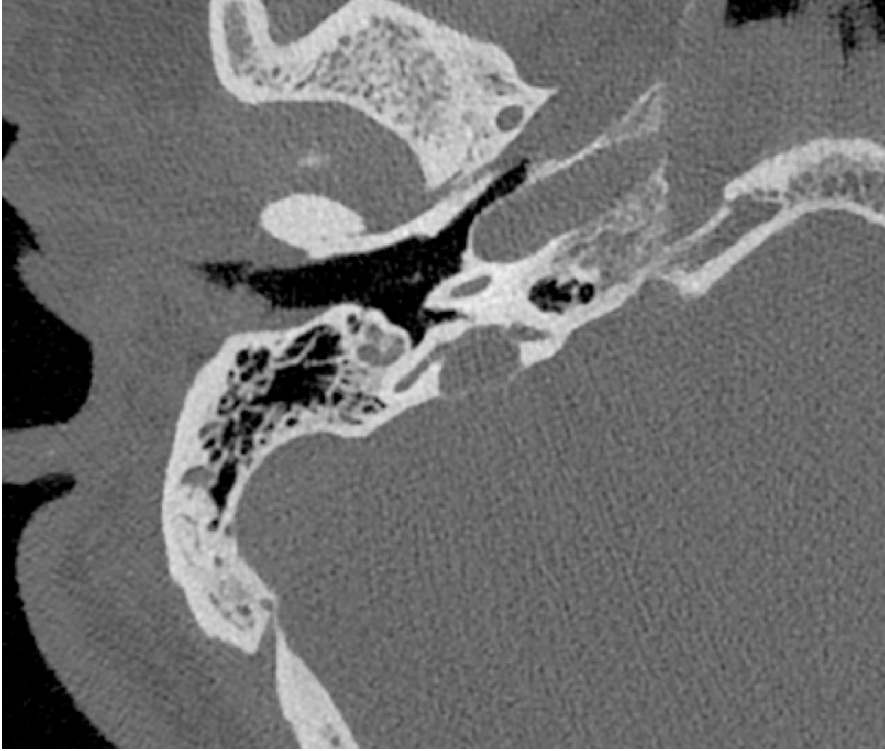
Axial CT scan demonstrating an osseous defect along the posterior wall of the posterior semicircular canal
